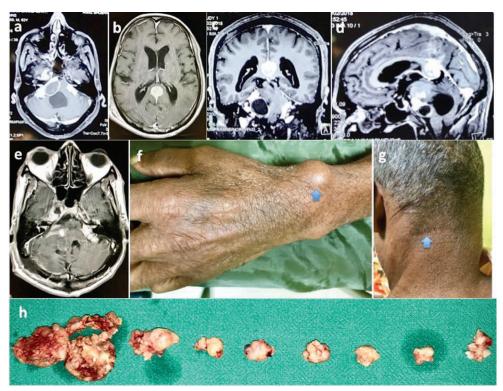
Contrast T1-weighted MRI images (axial, coronal, and sagittal) showing bilateral trigeminal schwannoma (right is larger than left) with bilateral multiple small schwannoma of seventh, eighth, and lower cranial nerves with velum interpositum meningioma (a-d). Postoperative axial T1-weighted contrast MRI showing excision of right-sided tumors with residual middle fossa component of right trigeminal schwannoma (e). Large subcutaneous nodule on radial aspect of left wrist (f) and old scar of previously operated schwannoma on left side of nape of neck (g). Excised tumors (eight in number) from right cerebellopontine angle region, largest was of trigeminal schwannoma (h).
